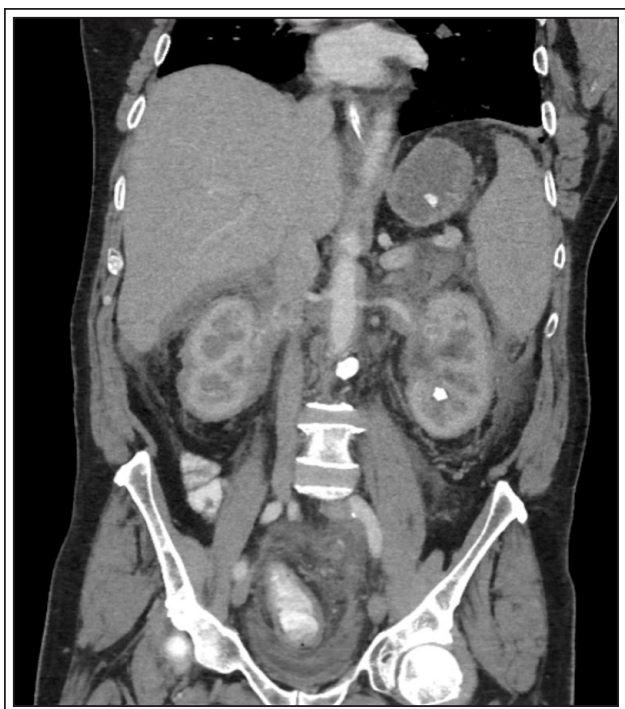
CT abdomen/pelvis from 2012 preceding his diagnosis of ECD. Note the classic radiographic finding of 'hairy' kidneys.
